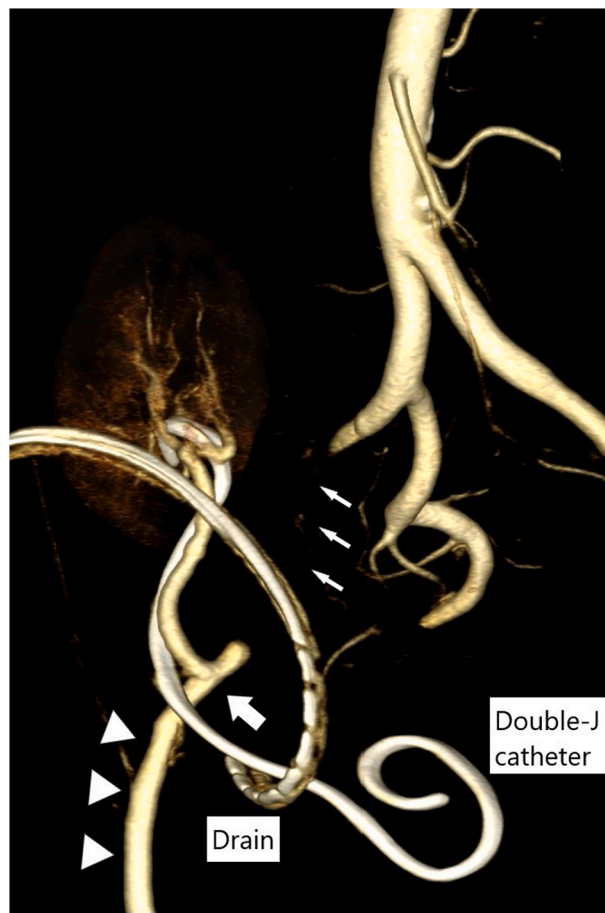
3D-reconstructed image of computed tomography angiogram showing non-opacification of the middle part of the right external iliac artery (small arrows). The graft arterial anastomosis (large arrow), distal external iliac artery and common femoral artery (arrowheads) were patent.
